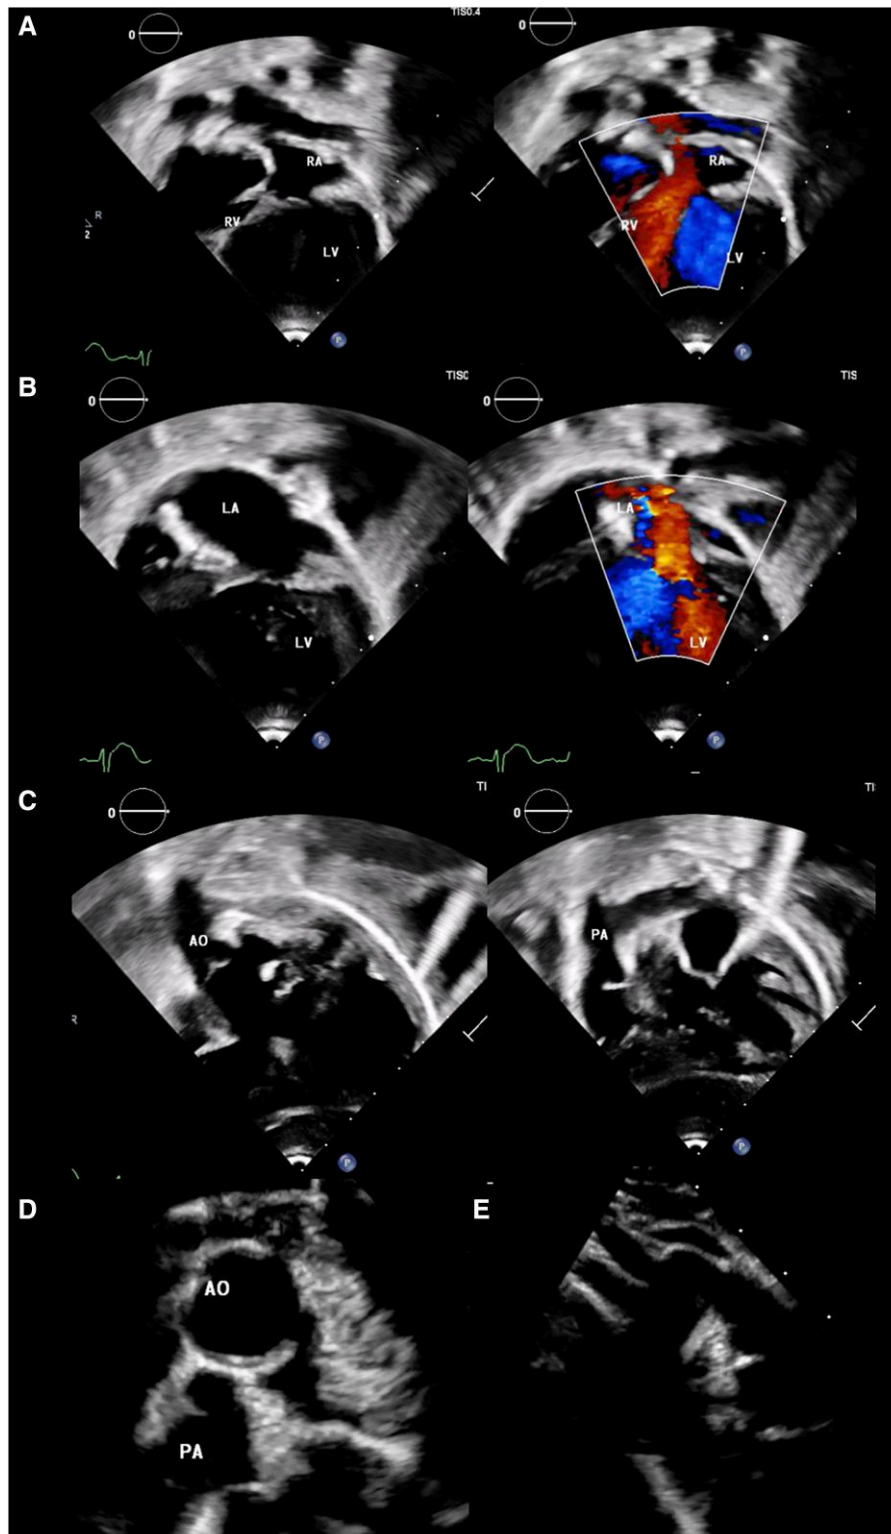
Echocardiography images demonstrate. (A) Left-sided right atrium connected to right-sided right ventricle; (B) right-sided left atrium connected to left-sided left ventricle; (C) double outlet right ventricle with two great arteries arising from right ventricle; (D) malposition of great artery with aorta left anterior to pulmonary artery; (E) right-sided aortic arch.
